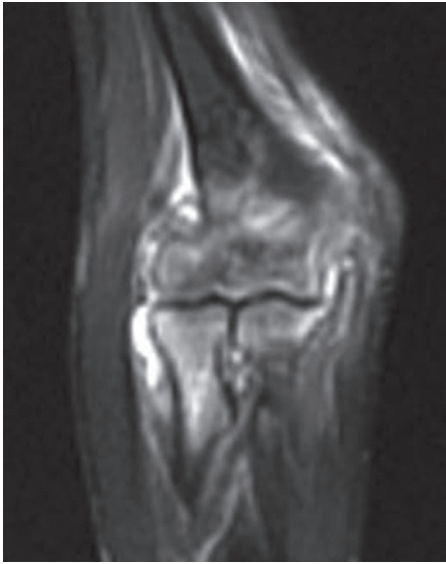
Elbow magnetic resonance imaging (MRI) Density change, marked contrast enhancement, changes in bone density, thickening of synovial structures, and contrast enhancement of the medullary bone marrow and effusion
